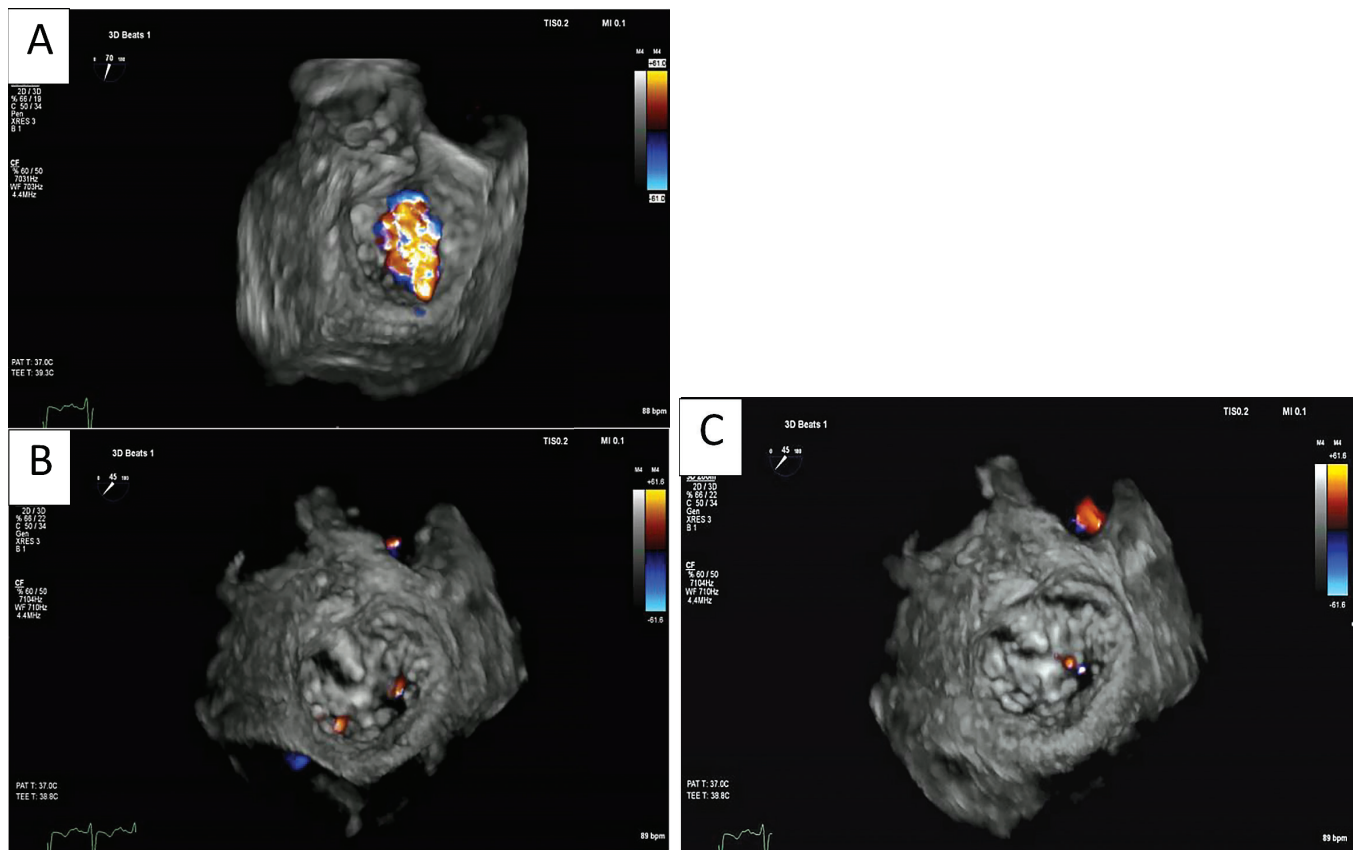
A. Before the procedure, three-dimensional (3D) transoesophageal echocardiogram in early systole showed a large central regurgitation jet, indicating severe functional mitral regurgitation. B. After the procedure, in early systole, 3D TEE showed two small side jets but no central defect. C. After the procedure, later in systole, 3D TEE showed only a minimal residual mitral regurgitation jet
